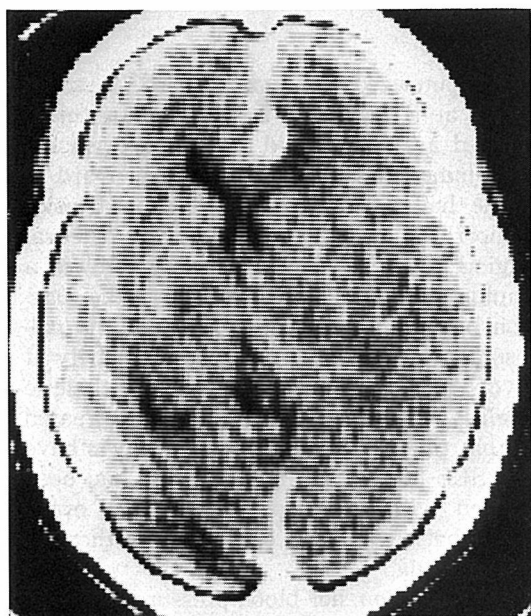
A CT scan without contrast-medium enhancement showing high-density lesion in the interhemispheric fissure and right medial frontal lobe with ventricular deformity.
